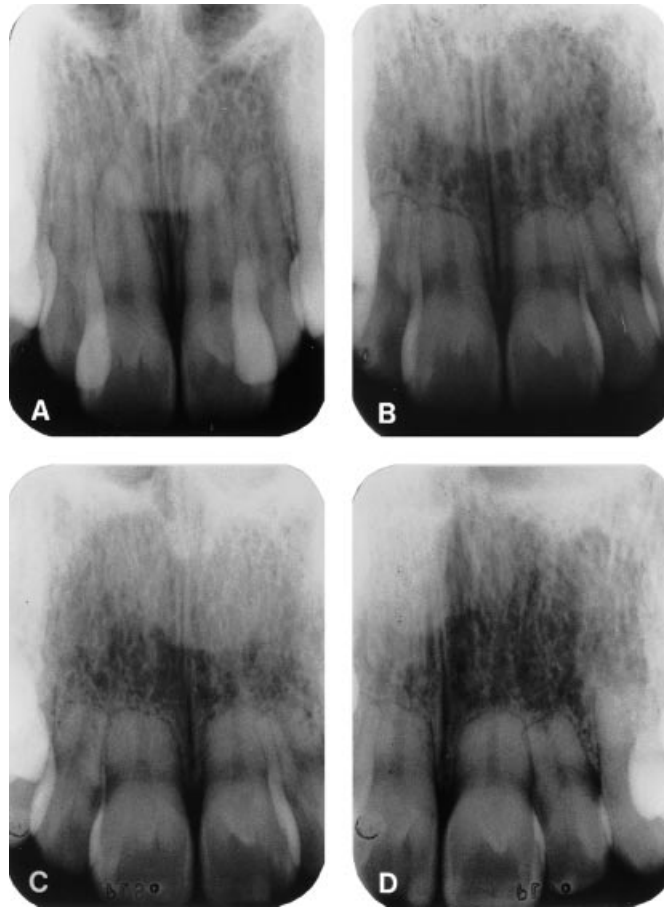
Radiographs of a patient, aged 31 years, with severe apical root resorption. Follow-up period 15 years. Retention with removable plate for 1 year after treatment. (A) Before treatment. (B) After treatment. Severe apical root resorption of maxillary incisors. (C,D) At the follow-up control. Total root length 12 to 22 <9 mm. Increased mobility of all four incisors. Periotest values 12 = 14; 11 = 12; 21 = 18; 22 = 18.
